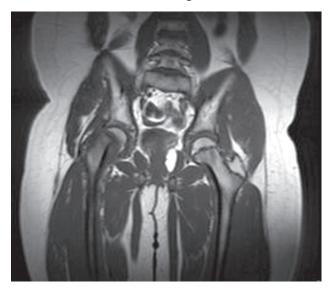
MRI scan of pelvis of a 12-year-old male patient K., coronal view
